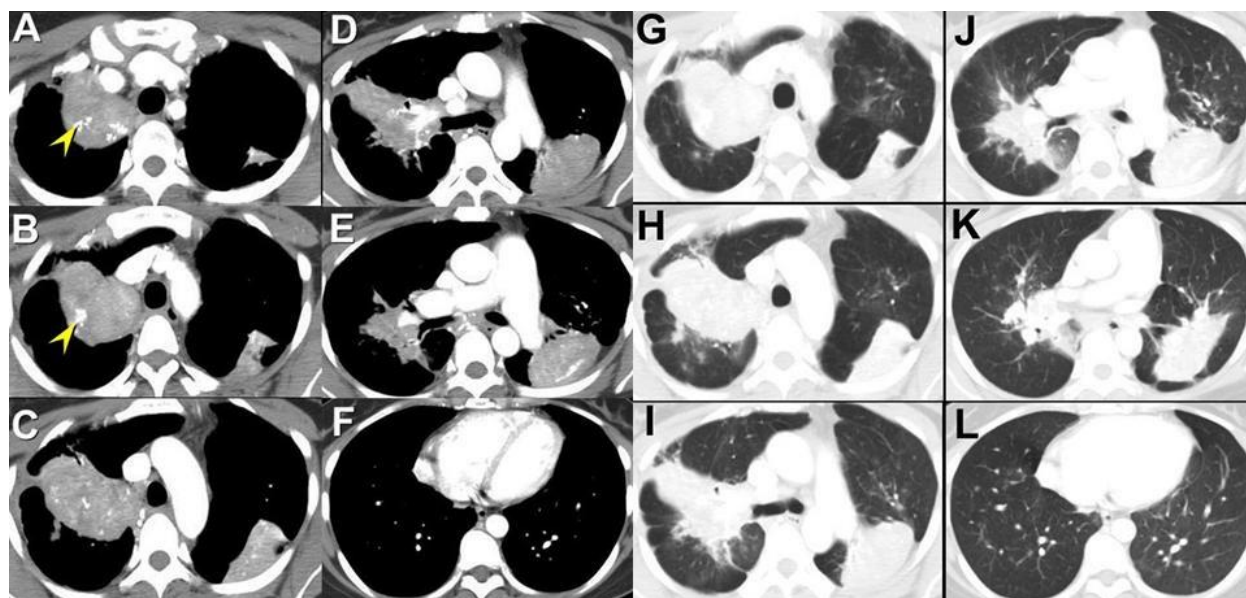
Representative images from axial enhanced thoracic CT displayed in soft tissue (A-F) and lung (G-L) windows.
